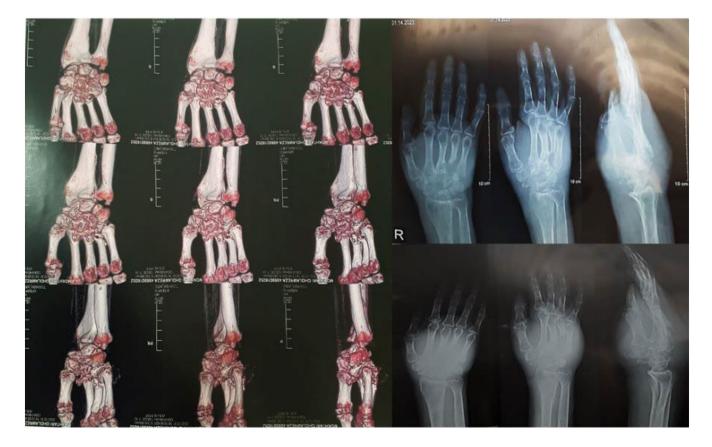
A plain radiograph showing the presence of an expansive and lytic lesion in the wrist.
